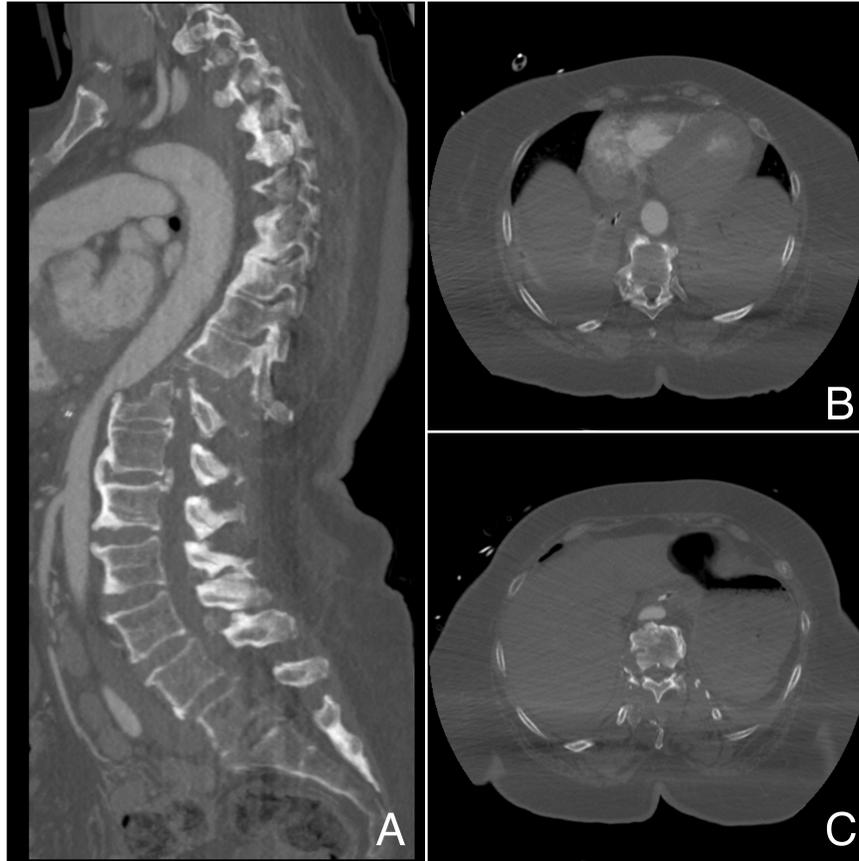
(A) Sagittal computed tomography angiography showing the Chance fracture at T11 with anterior dislocation of the caudal spinal column and aortic compression. (B) Axial computed tomography angiography scan at vertebral level T10 showing normal caliber of the aorta. (C) Axial computed tomography angiography scan at the inferior portion of T11 showing compression of the aorta with over 2-fold decrease in cross-sectional area.
